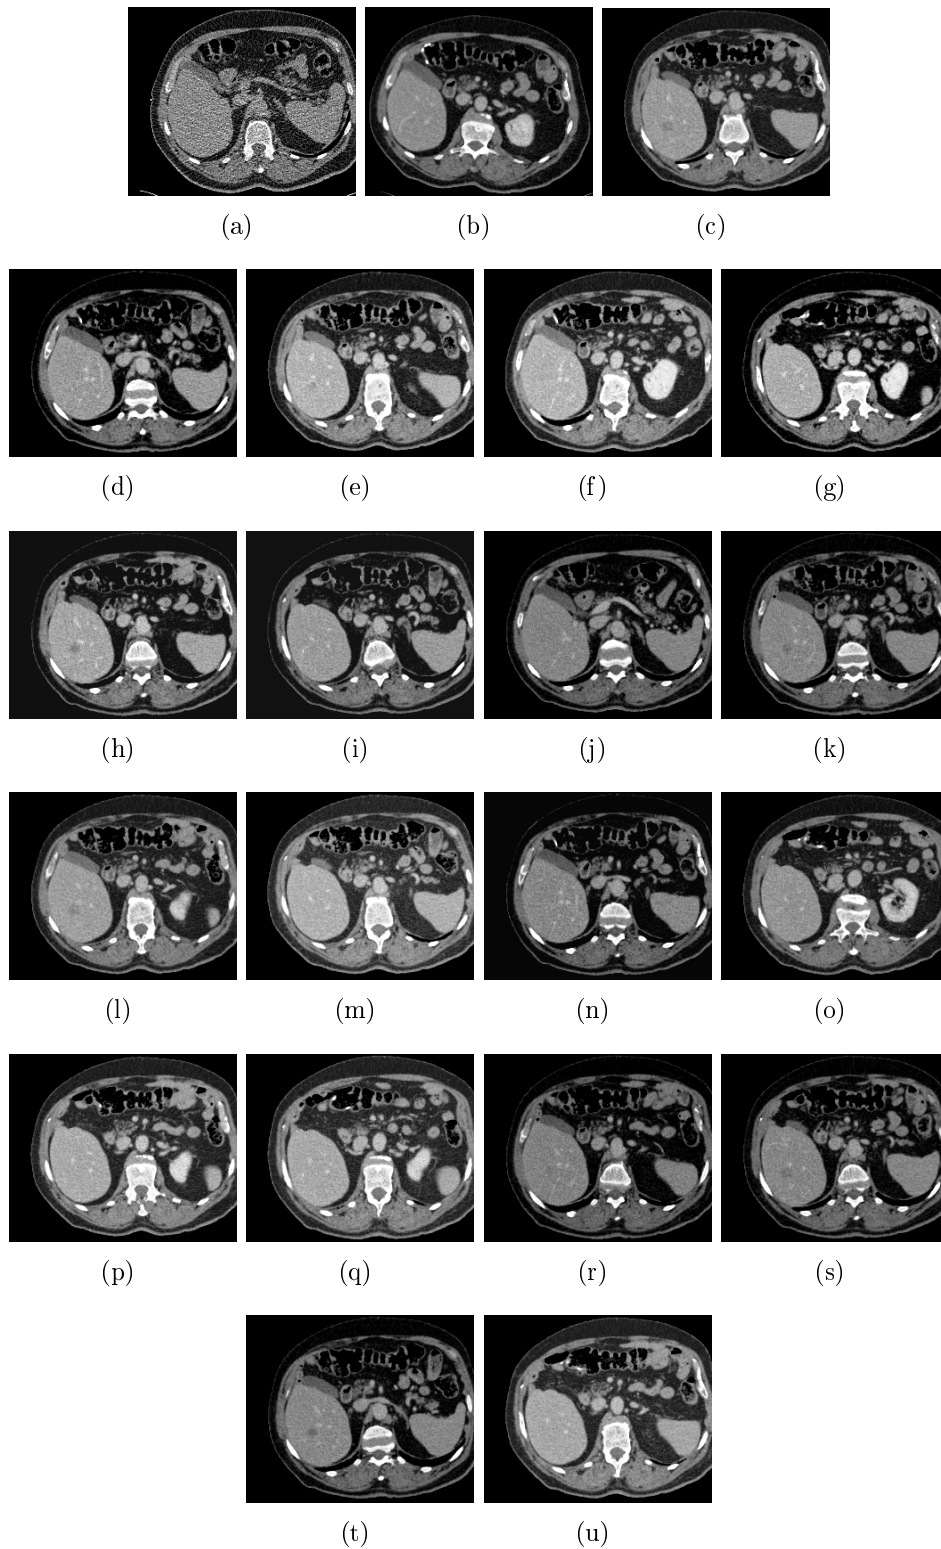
AM-estimator: (a) represents the CT-fluoro slice. (b) represents the initial pose in the volume. (c) represents the estimated minimum. From (d) to (u): the 2D views represent CEPs.
